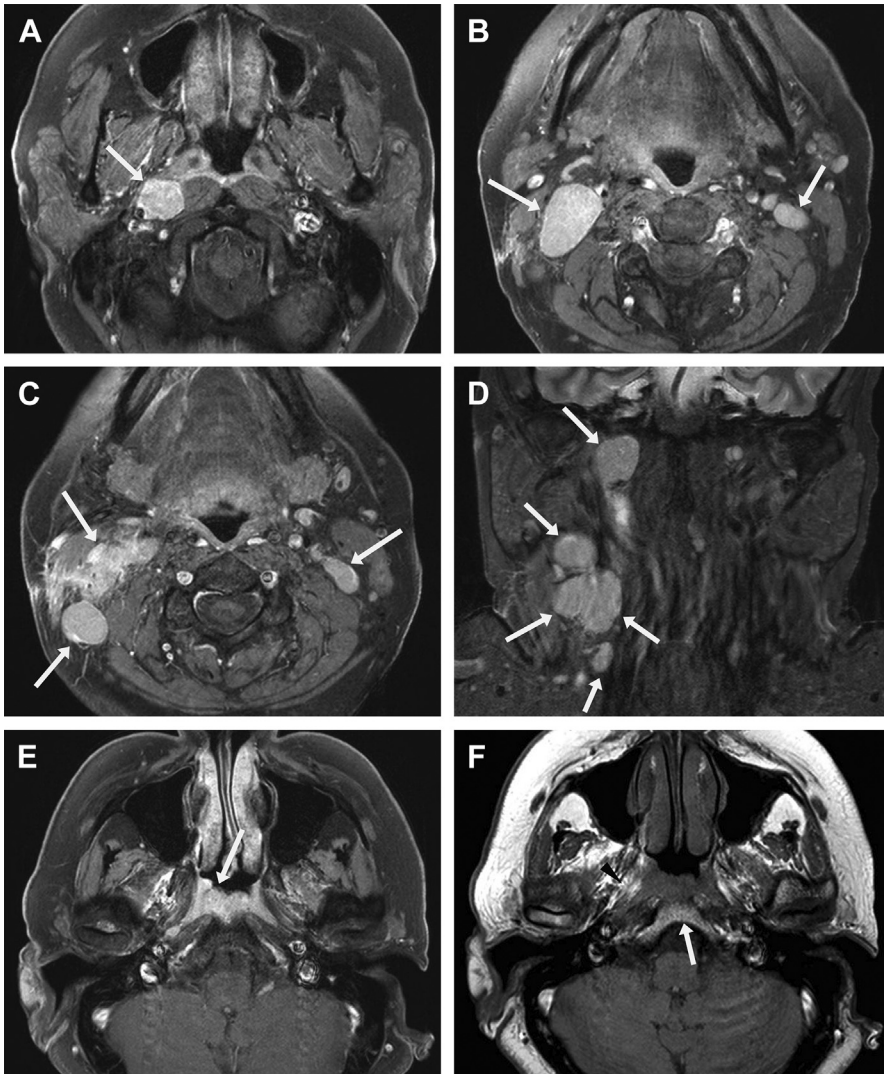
A 48-year-old woman with EBV and NPC. She initially presented to her primary care physician with a right neck mass, and magnetic resonance (MR) imaging of the nasopharynx and neck was performed. (A–C) Axial post-contrast T1-weighted images show avidly enhancing nodes in the lateral retropharyngeal region (node of Rouvière) (arrow in A) and bilateral level II nodes (arrows in B and C). (D) Coronal short-tau inversion recovery image shows the T2-hyperintense nodes (arrows). (E) Axial postcontrast fat-saturated T1-weighted sequence at the level of the nasopharynx shows nodular soft tissue thickening in the nasopharynx representing the primary tumor, which is small relative to the nodes. Mass effect causes effacement of the fossae of Rosenmüller, more on the right than the left (arrows). (F) Axial noncontrast T1-weighted sequence helps to assess marrow signal in the clivus (arrow) and the parapharyngeal fat (arrowhead); in this case, both are uninvolved. The patient subsequently underwent nodal biopsy, which revealed EBV and metastatic carcinoma.
